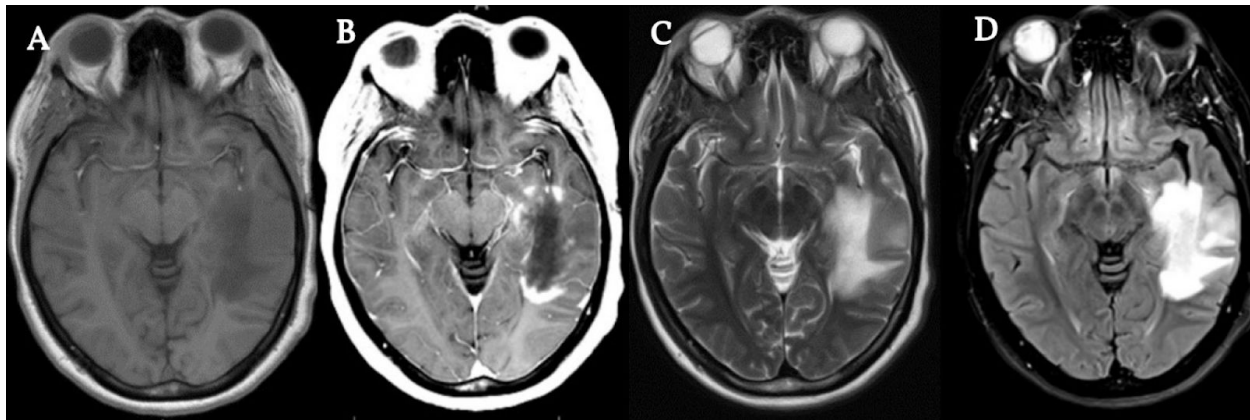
Patient 1 MRI Imaging (A) T1 Pre Contrast (B) T1 Post Contrast (C) Axial T2 (D) Axial Flair. Imaging shows a large ovoid lesion in the left temporal lobe. Open-ring enhancement is seen with no mass effect present. Several additional smaller lesions are present within the right superior frontal gyrus, left pons, and left ventral medulla.
